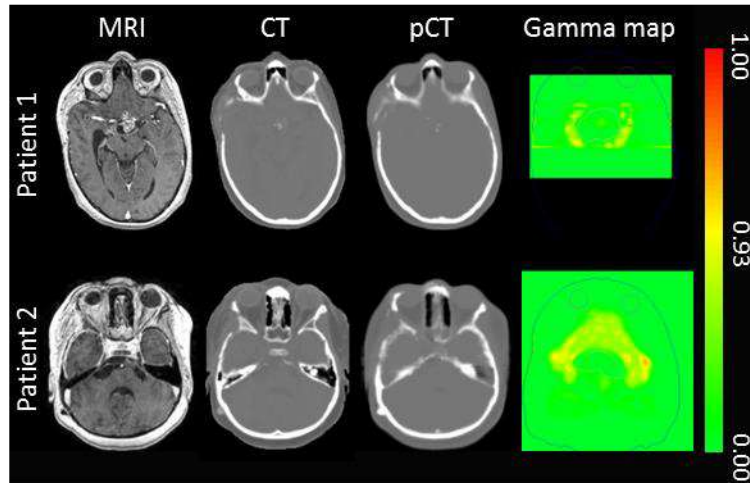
T1-Gd MRI, CT, pCT and gamma map for the 3%/3mm criterion presented for Patient 1 (17 years old, 6 beams-based treatment) and Patient 2 (6 years old, 6 beams-based treatment). To improve visibility, outer and eyes contours are displayed on the gamma maps.
